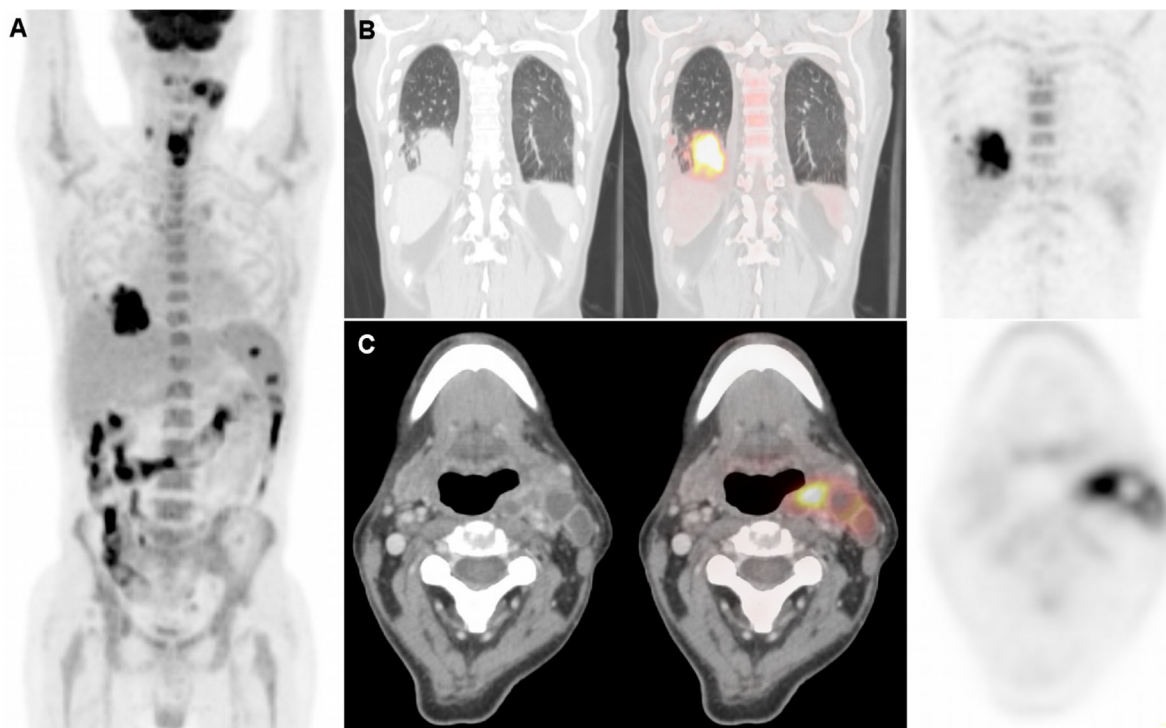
Patient 4. a Anterior view maximum intensity projection showing increased pathological FDG uptake in the right lung, left neck, anterior neck, and colon. b Coronal view CT, FDG-PET/CT fusion, and maximum intensity projection images of increased pathological FDG
